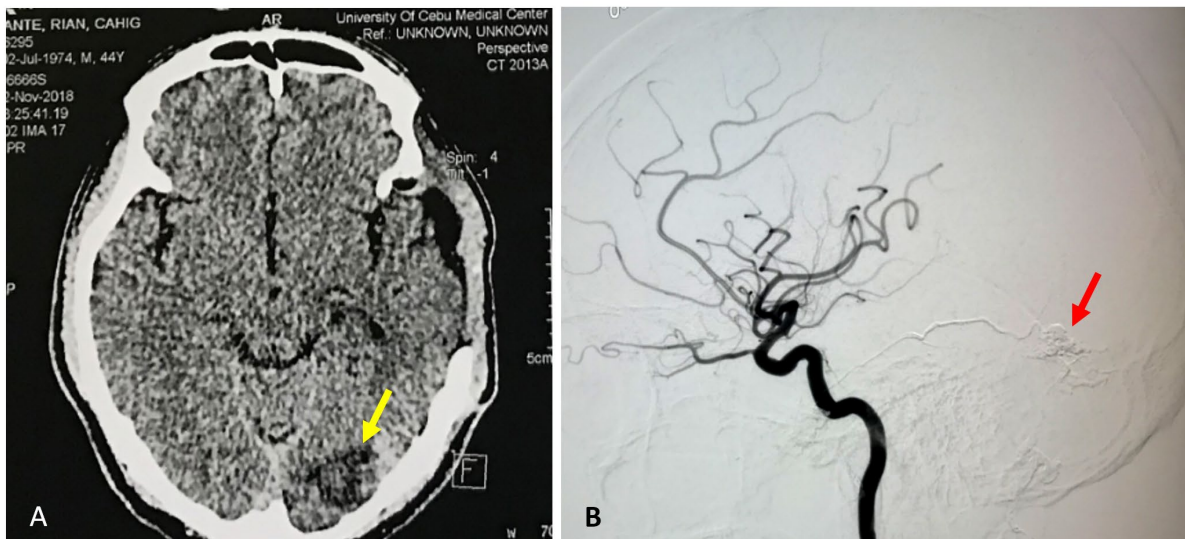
Repeat imaging after 3 months. (A) Axial sectional of CT scan showing Encephalomalacia (yellow arrow) at the left occipital lobe. (B) Four-vessel angiogram showing completely obliterated dAVF (red arrow).
